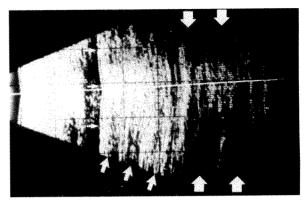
(Whitacre). When the head was face down and the ultrasound probe parallel with the visual axis, the meniscus produced by a small amount of intraocular fluid was apparent as a well-formed echo (fine arrows). Reverberations (medium arrows) and shadowing (large arrows) were present behind the meniscus.
